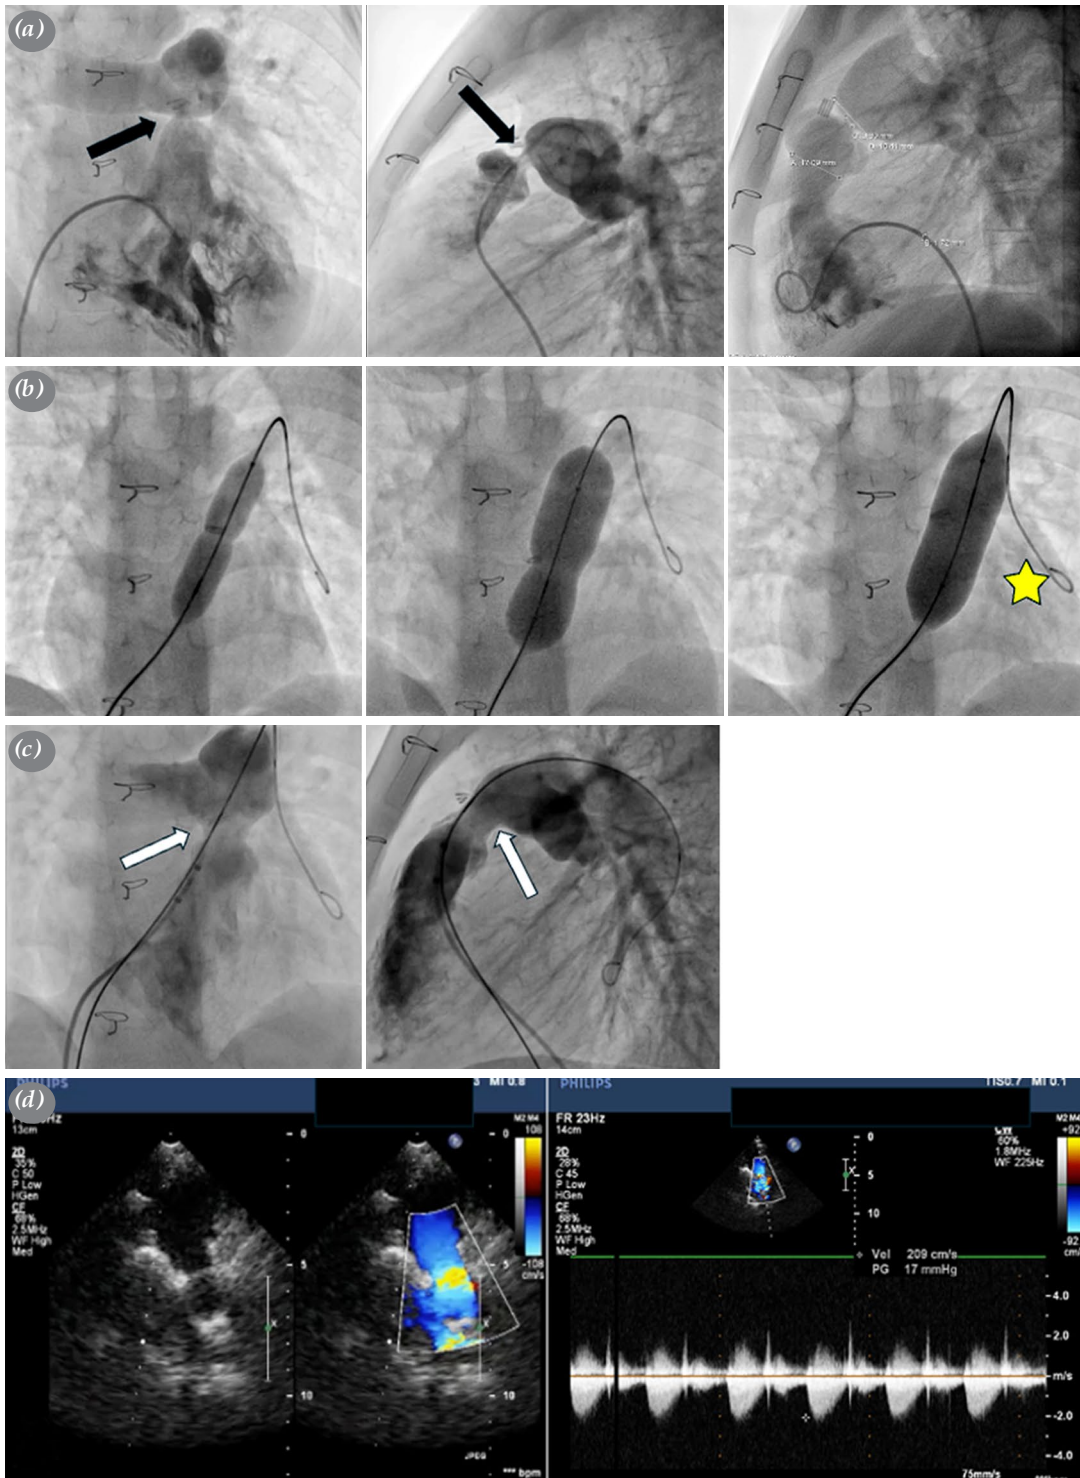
Catheter angiography was performed on a five-year-old girl weighing 16 kg due to the restrictive VSDs. (a) Black arrows show the narrowed pulmonary artery due to surgical banding. (b) Gradual dilation was performed with 11-, 14-, and 18-mm Z-Med balloons. Dilation with an 18-mm Z-Med balloon resulted in the loss of indentation (yellow star). (c) Total debanding was observed during control injections, and pressure measurements showed a peak RV-PA of 7 mmHg. (d) Echocardiographic examination revealed no anatomical narrowing of the pulmonary artery due to banding, and a peak gradient of 17 mmHg was observed on continuous wave Doppler, with no pulmonary regurgitation.
